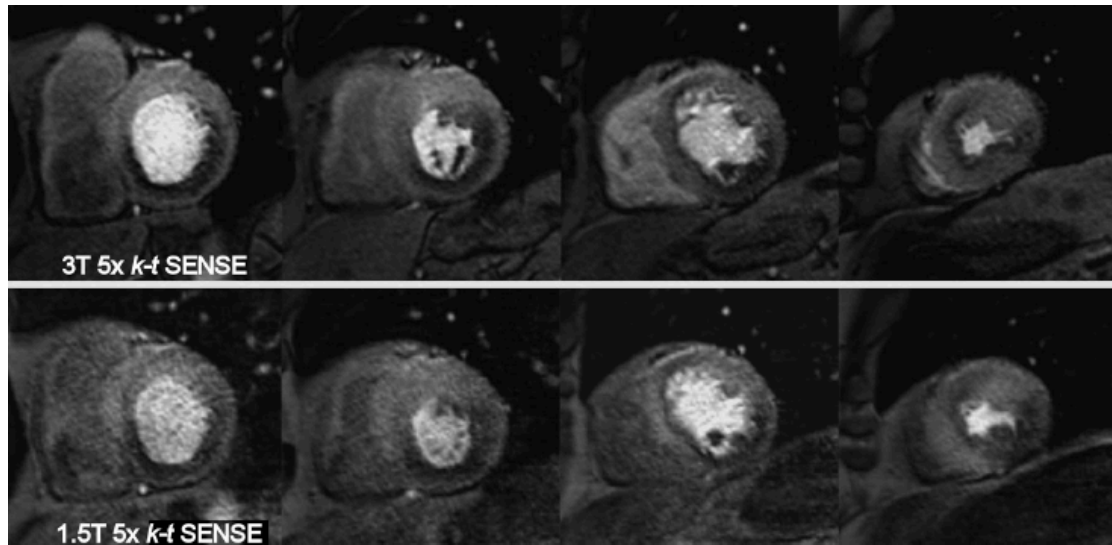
Fivefold (5x) k-t SENSE–accelerated adenosine-induced stress 3.0- and 1.5-T perfusion MR images in a 65-year-old patient suspected of having coronary artery disease. Four sections in the double-oblique short-axis orientation from base (left) to apex (right) were acquired. Both data sets have similar diagnostic content, but image quality at 3.0 T is superior. Data sets show inferior and lateral ischaemia in basal and midcavity section and anteroseptal ischaemia in apical sections. [adapted from Plein et al *Radiology* 2008²²³].
